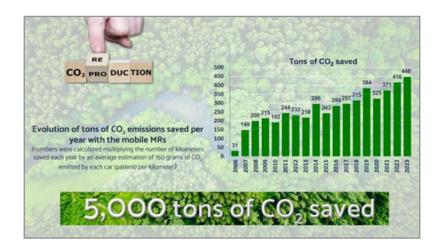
Evolution of tons of CO2 saved per year with the mobile MRI units
